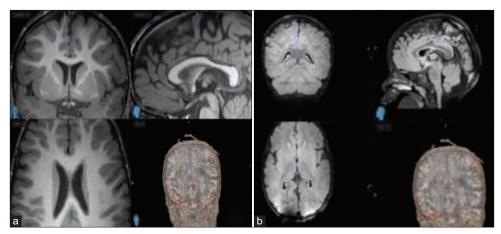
(a and b) Preoperative magnetic resonance imaging is coregistered to the frameless stereotactic navigation.
